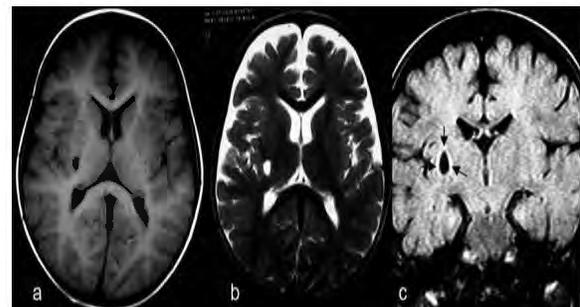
A dilated PVS at the posterior limb of the right internal capsule. It is isointense at T1W image (a), hyperintense at T2W image (b). The lesion has peripheral high signal intensity rim at the FLAIR images.
